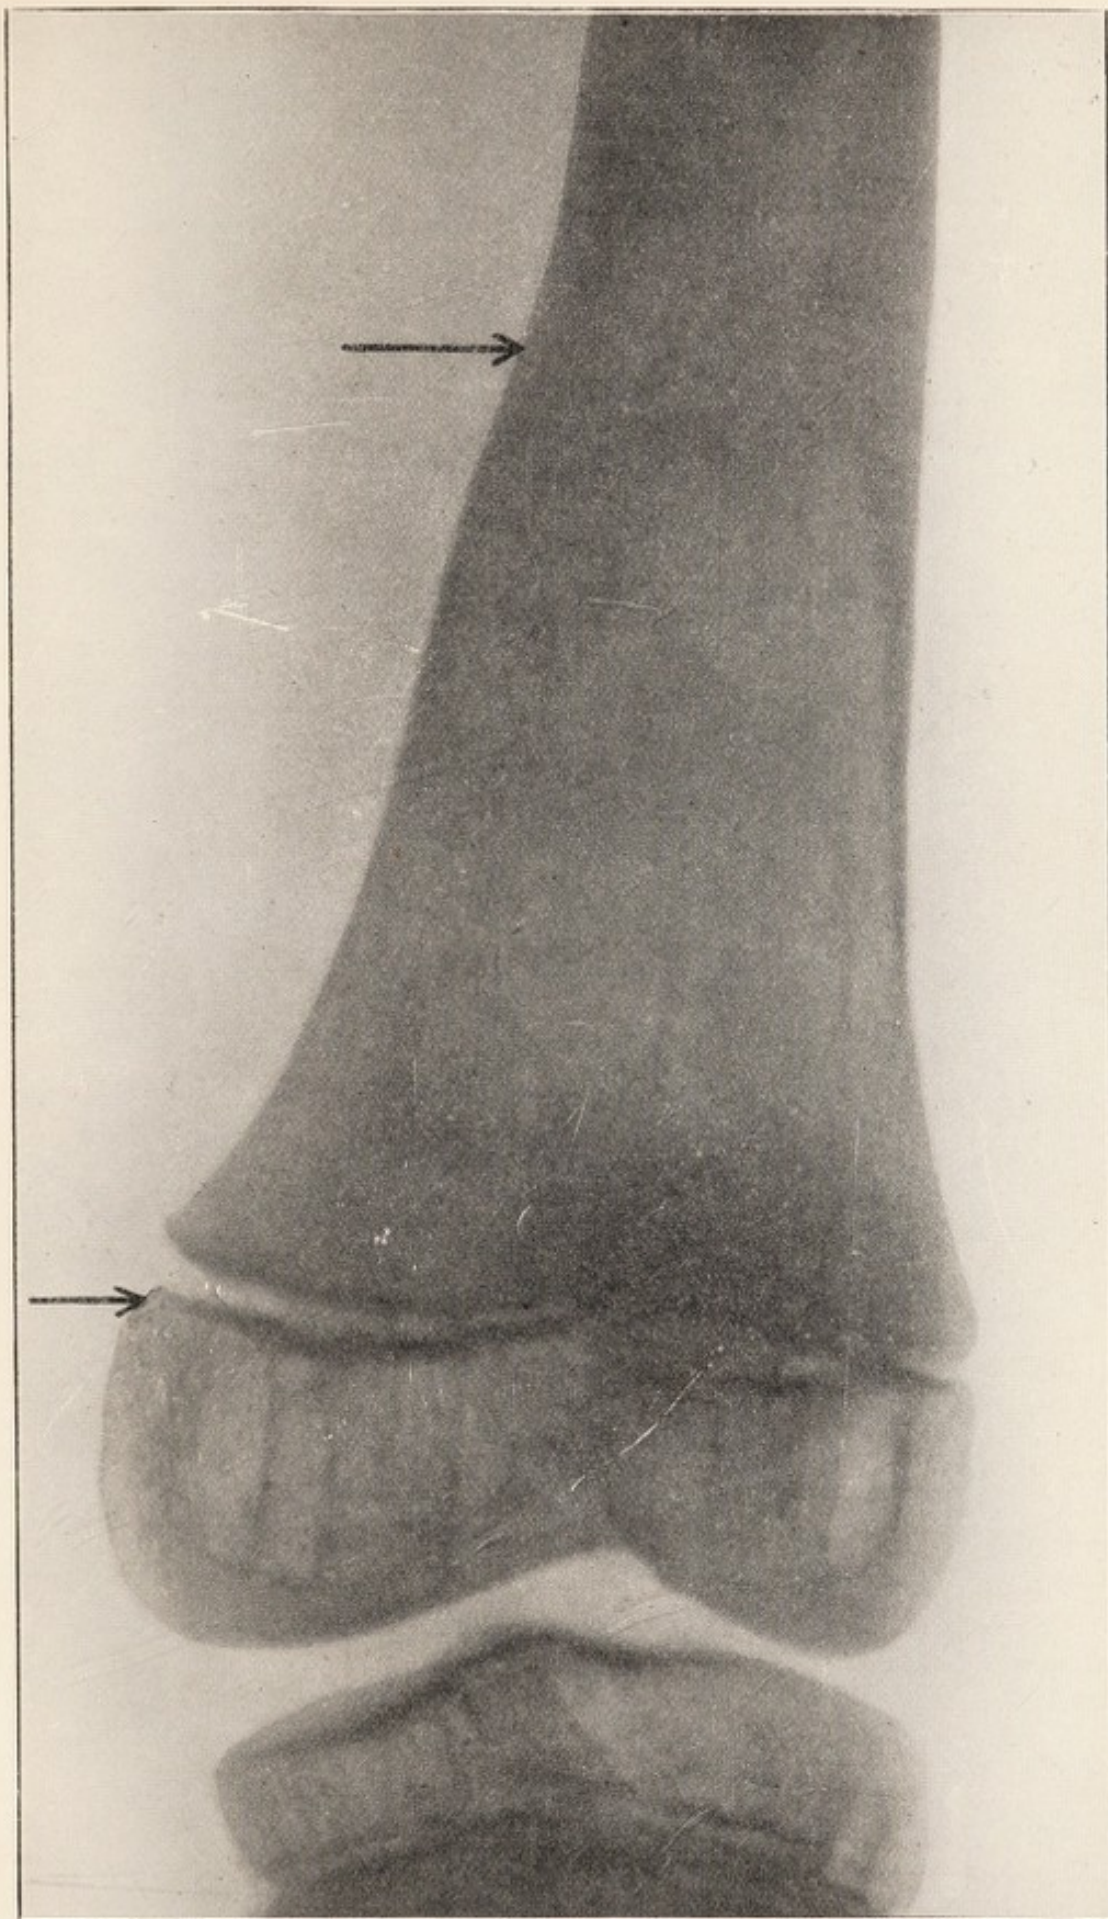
X-ray of first case, four years after operation. The lower third of the shaft of the femur was removed (between the arrows) and was accurately reformed as shown. Functional result perfect.
